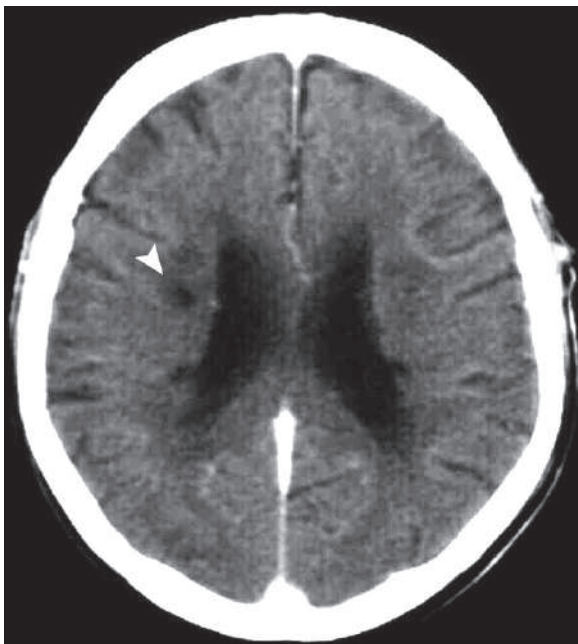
Axial brain CT image shows acute lacunar infarction in the right centrum semiovale with small ring of cytotoxic edema around it (*arrowhead*)
